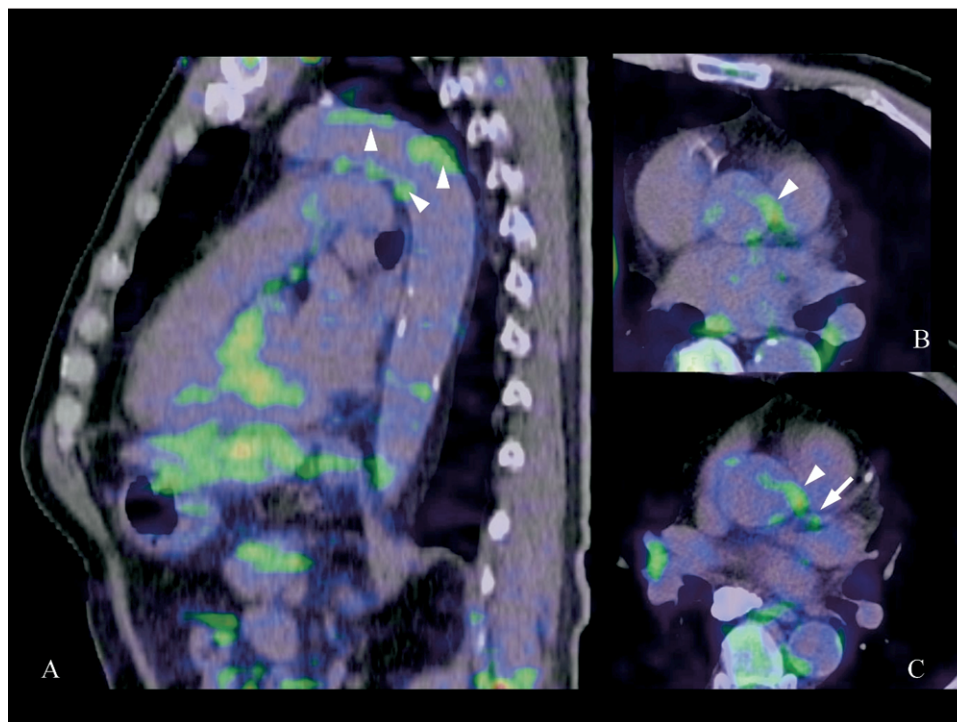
F-18 FDG-PET/CT images in sagittal (A) and axial (B and C) views showing uptake in aortic arch (*arrowheads* in A) and ascending aortic root (*arrowheads* in B and C), as well as a structure that appears to be within left main coronary artery (*arrow* in C). The maximal standard uptake values in the lesions were 2.5 in the aorta and 2.1 in the left main artery. In comparison, the maximal standard uptake value was 1.2 in the adjacent myocardial region.
